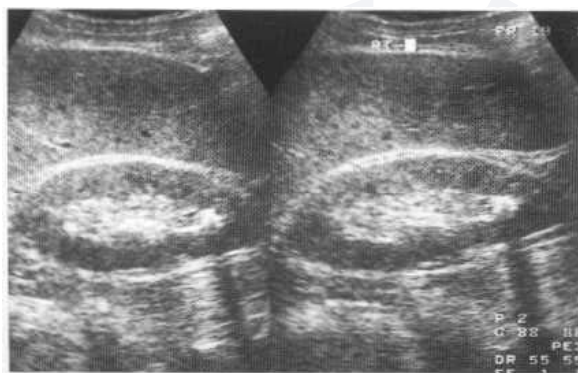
Small solitary renal calculus on ultrasound seen as an echogenic focus with marked distal acoustic shadowing.
